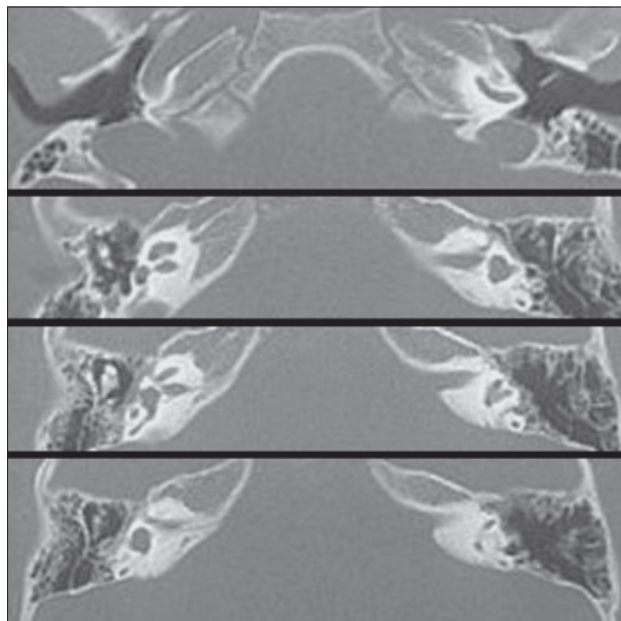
CT scan of bilateral LSC (Lateral Semicircular Canal) aplasia.
